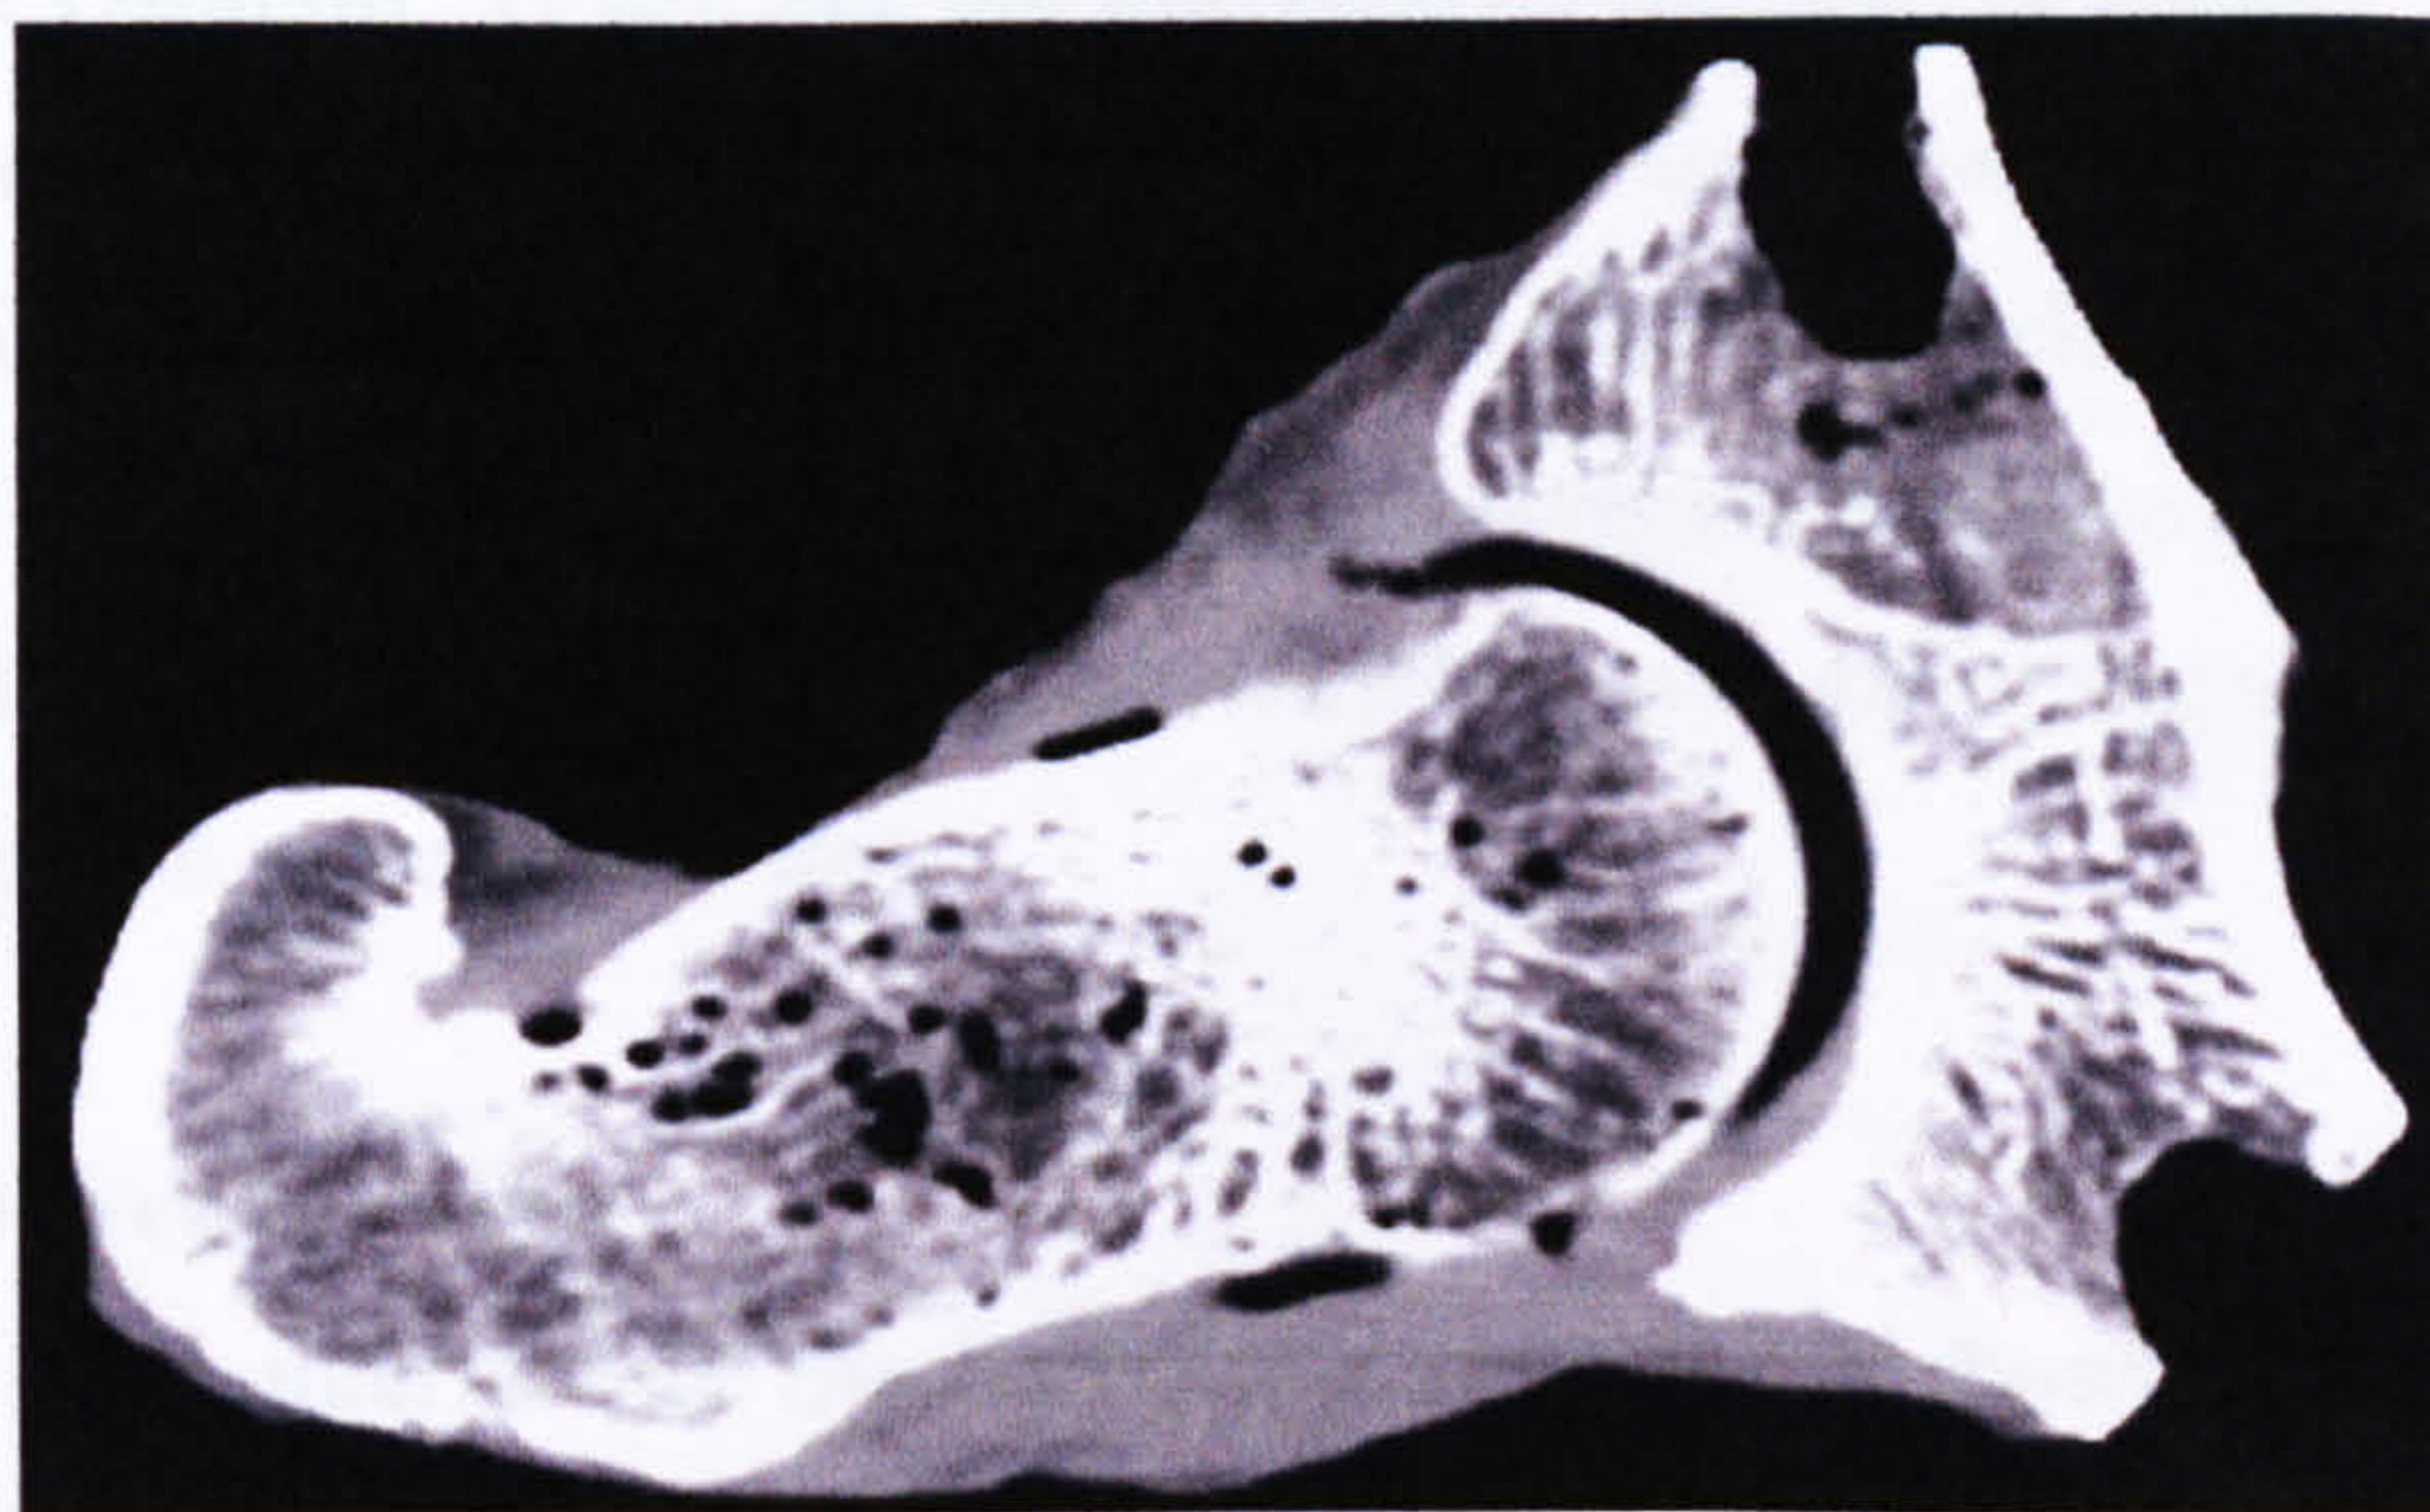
CT scan of hip joint comprising bones and ligaments.
